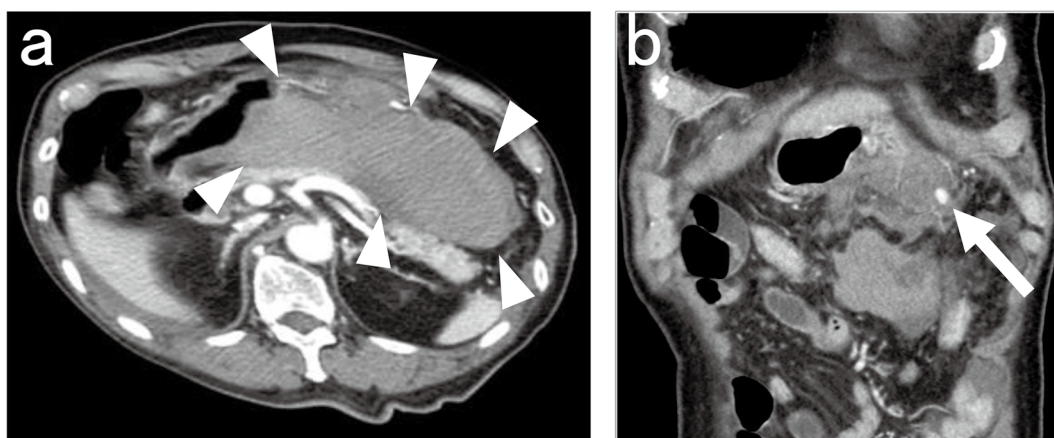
Emergency contrast-enhanced computed tomography revealed a peritoneal hematoma (arrowhead) and an aneurysm (arrow) in the right gastroepiploic artery that was not observed on previous computed tomography images. a: Image of intraperitoneal hematoma. b: Image of the aneurysm in the right gastroepiploic artery.
